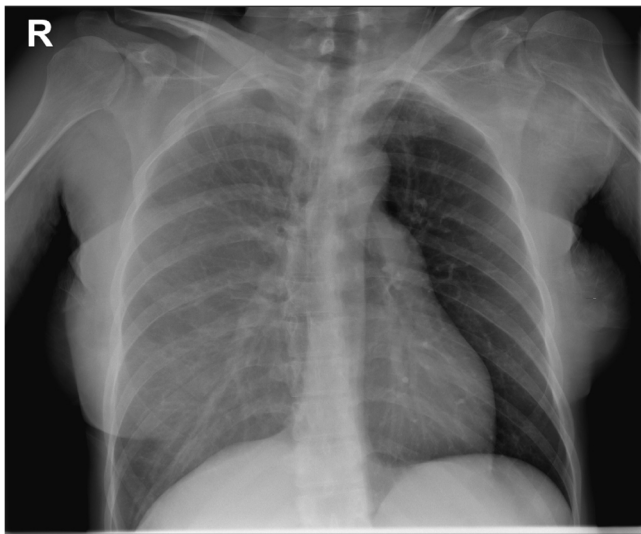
Chest x-ray showed pleural effusion on the right side.
